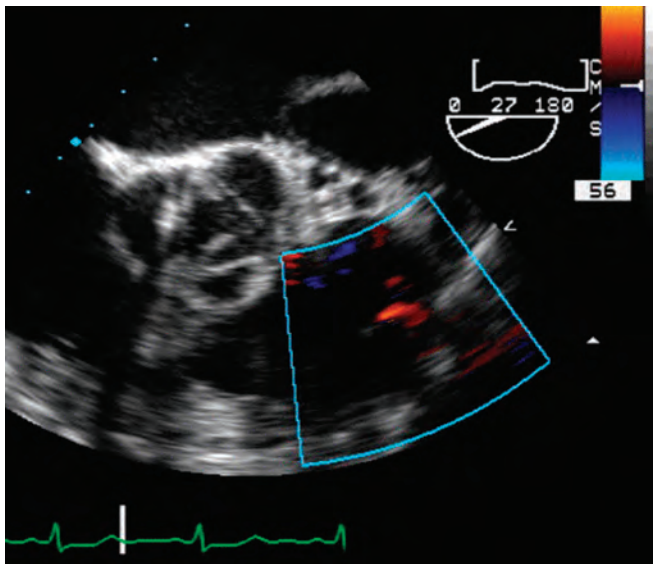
Midesophageal short-axis view of the aortic valve in diastole (at 27 degrees of rotation). The aortic leaflets appear normal. There is prolapse of the intimal dissection flap through the aortic valve, preventing diastolic coaptation and giving the appearance of a “double aortic valve.” Severe aortic regurgitation results from this mechanism, as shown in Fig. 23.43. This view also allows for assessment of right ventricular function, in particular, right ventricular hypokinesis caused by ischemia from right coronary dissection. Color-flow Doppler interrogation in this view shows trace pulmonic insufficiency, a common incidental finding. There is also a small pericardial collection evident: This is the residual from the hemopericardium that was drained at pericardiotomy. Before pericardiotomy, the hemopericardium was under tension and had resulted in severe cardiac tamponade.
